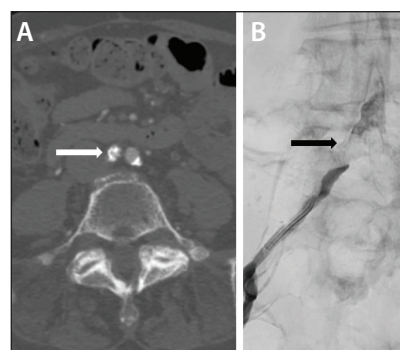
CTA demonstrating flush occlusion of the right CIA, with dense calcification (white arrow) (A). Initial angiogram confirming the flush occlusion of the right CIA (black arrow) (B).
